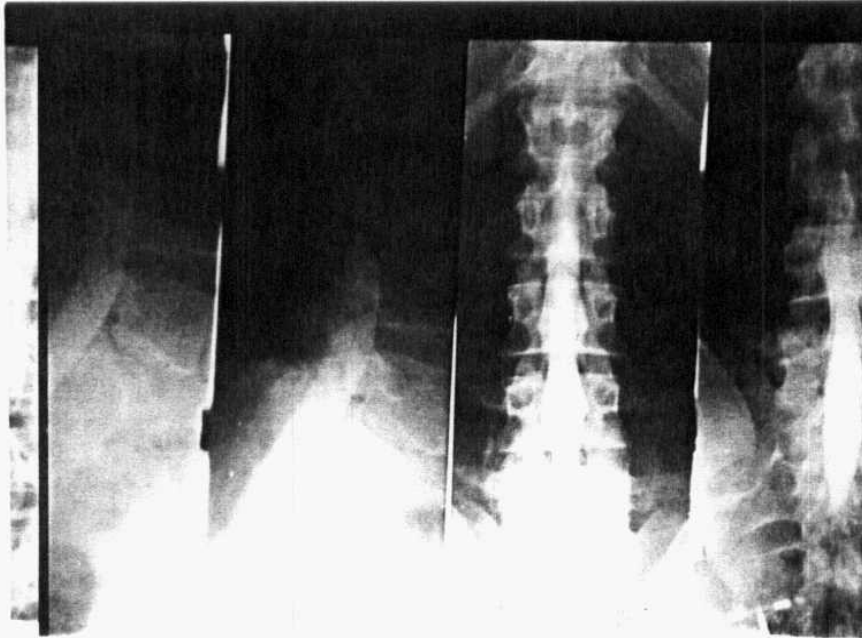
Myelography of a man showing negative result. MRI showed degenerative disc at L5S1 which could not be seen by myelography due to wide canal at this level.
